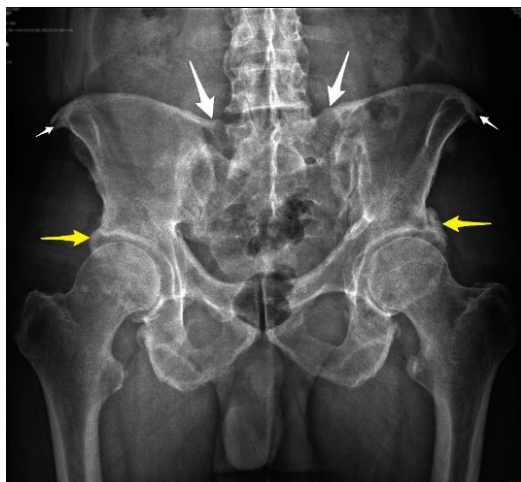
Anteroposterior (AP) radiograph of the pelvis shows calcification of iliolumbar ligament (big white arrows), osseous proliferation, and irregular bony excrescences (small white arrows), calcification of the superior acetabular margins (yellow arrows).
